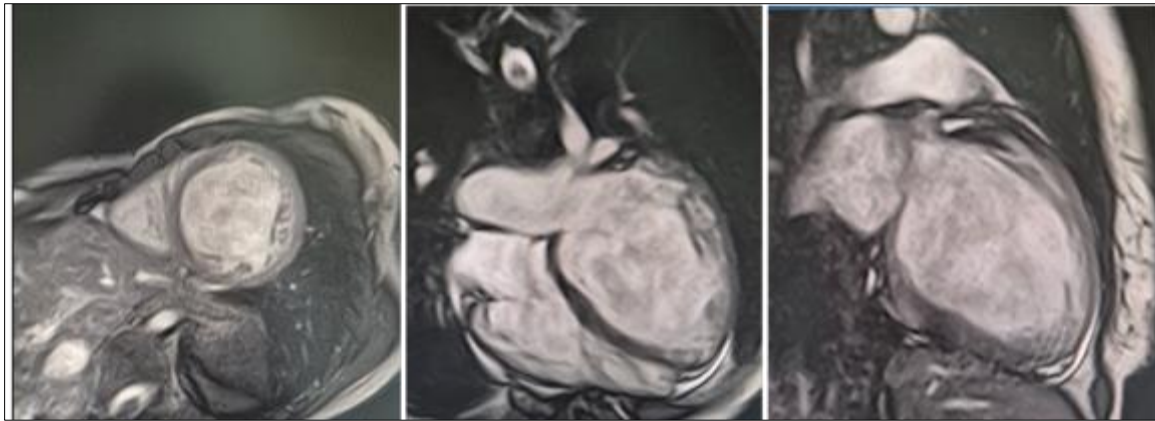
Cine MRI sequences showing a dilated left ventricle with global hypokinesia
